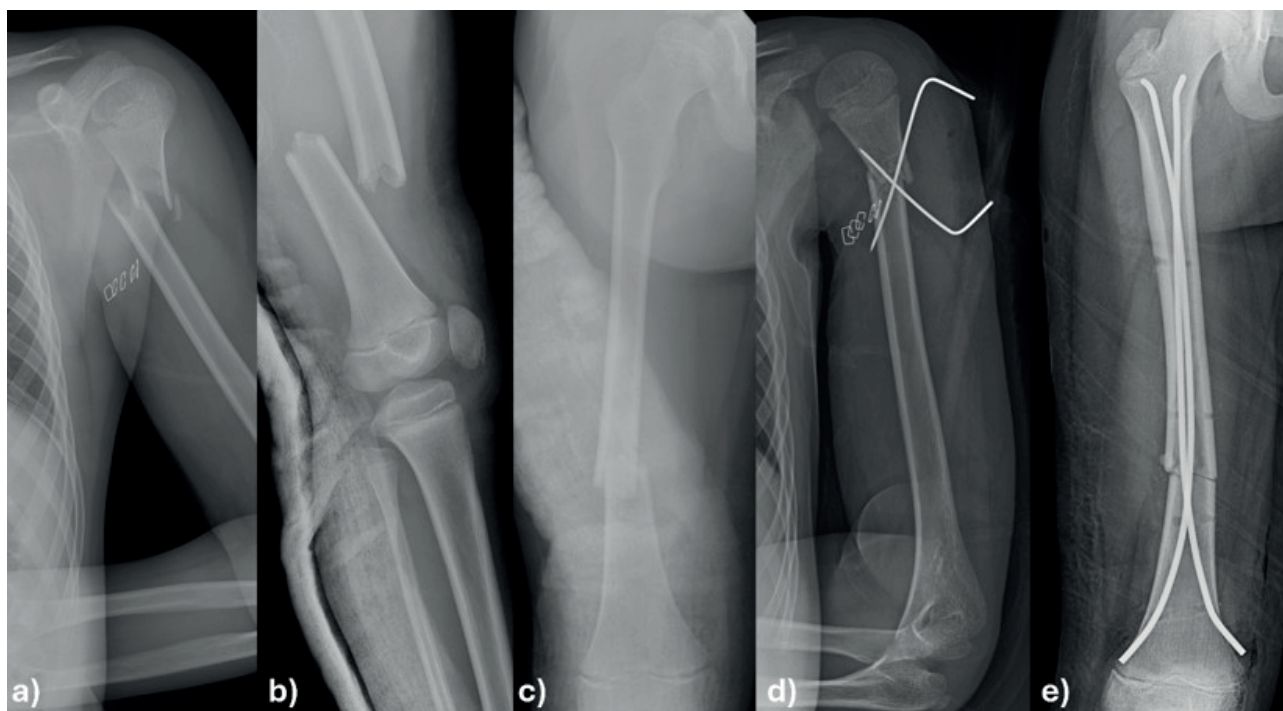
Radiographs of a 12-year-old male polytrauma patient following a traffic accident, referred intubated from a level 1 hospital
